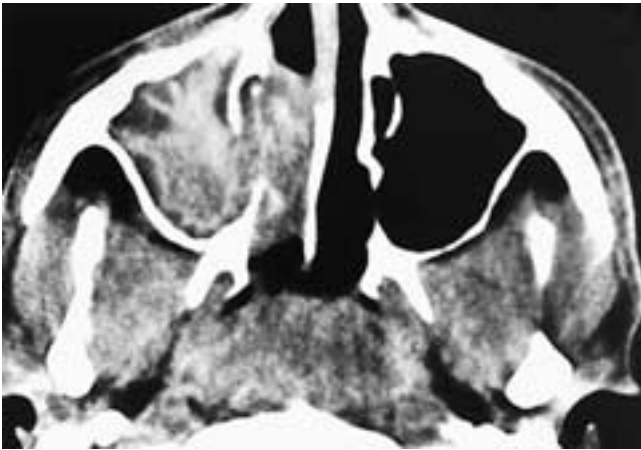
Axial CT scan shows a stellate high-attenuation soft-tissue mass in the right maxillary sinus and nasal fossa. The mass is separated from the bone by a thin zone of mucoid attenuation material. There is focal destruction of the medial antral wall. This patient had aspergillosis with an aspergilloma.
